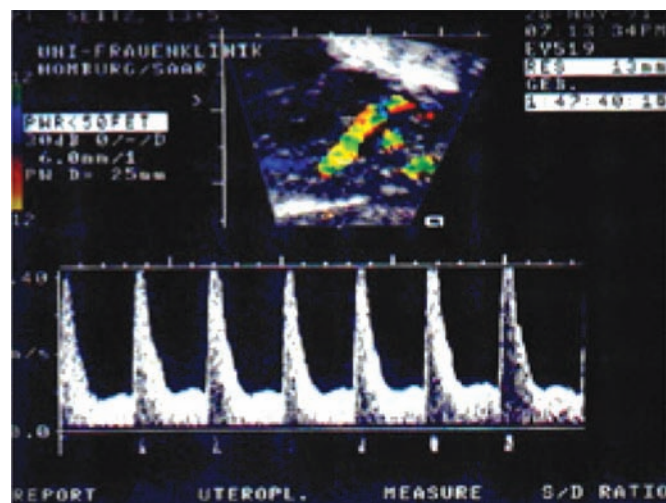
Doppler sonography of uterine artery in the first trimester of pregnancy (7+6 weeks) with early notch.
